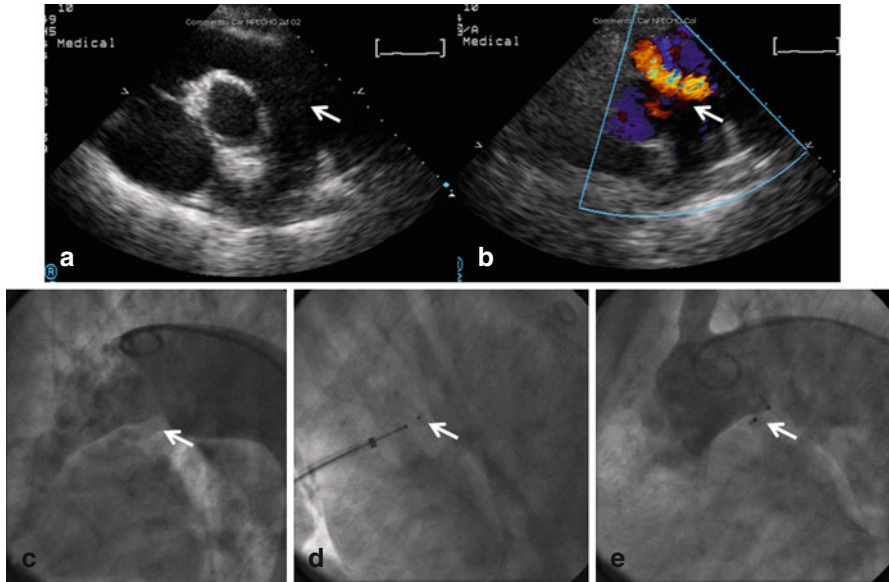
(a–e) Patent ductus arteriosus (PDA) pre- and post-percutaneous closure. *White arrow* identifies findings. (a) Echocardiogram showing pulmonary artery dilation. (b) High velocity color jet into the left pulmonary artery. (c) Aortography showing aorta-pulmonary artery shunt. (d) Placement of percutaneous delivery of an Amplatzer occluder. (e) Post-occlusion aortogram showing closure of the PDA
